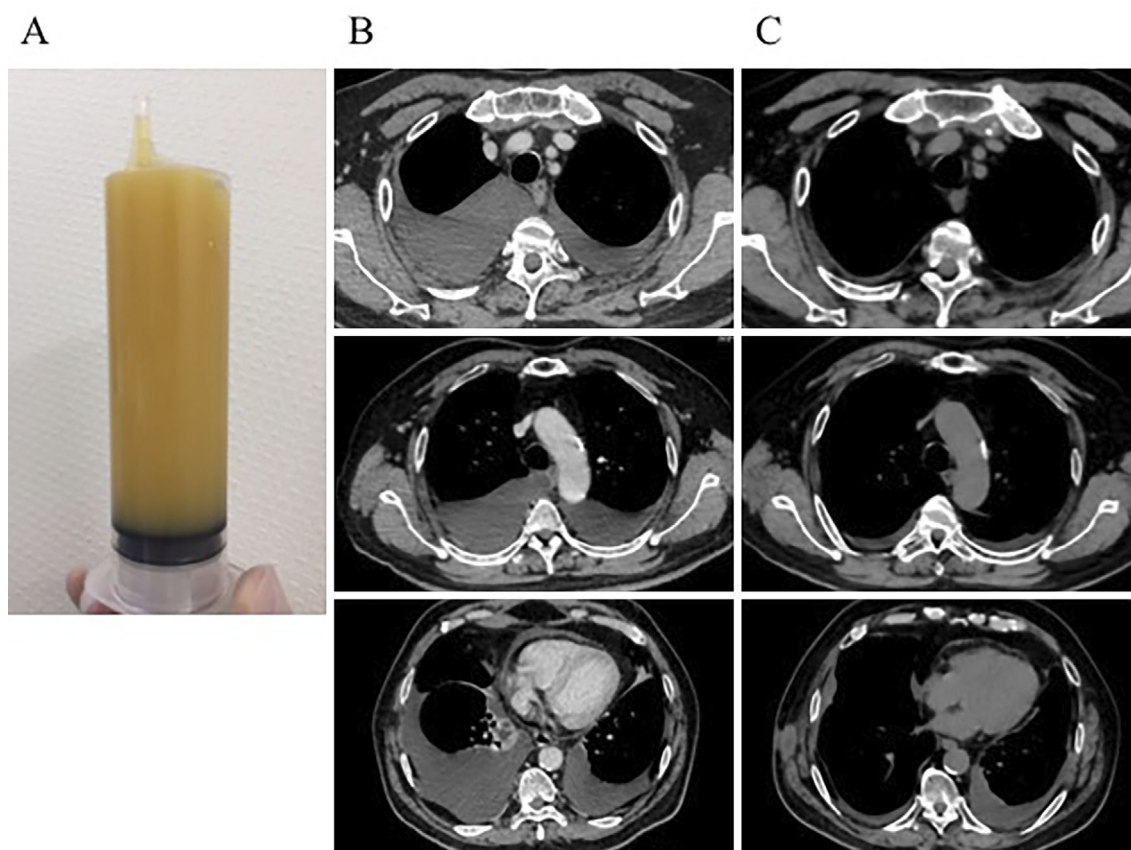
Pleural effusion and CT images before and after treatment. The right pleural effusion appeared as turbid yellow fluid (A). Bilateral pleural effusion and pericardial effusion were seen at the second admission (B). After treatment with a combination of high-dose corticosteroids and rituximab, the pleural and pericardial effusion was significantly decreased (C).
